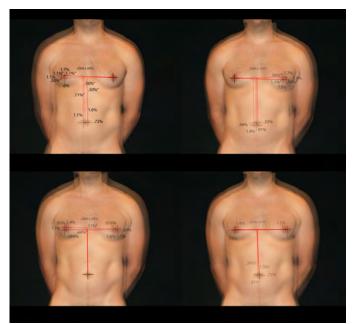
Analysis of variance in image capture by the three photographers in Figure 8 who had different levels of photographic experience and familiarity with the imaging protocol. The percent variances shown in each image correspond to the alignment of the following points: top left: left nipple; top right: right nipple; bottom left: umbilicus; and bottom right: the alignment of the points where the inter-nipple line and a vertical line from the umbilicus meet. All image variances are less than 1.7%, well within limits for valid scientific analysis, while image variance in CT and MRI can be as high as 10%.
